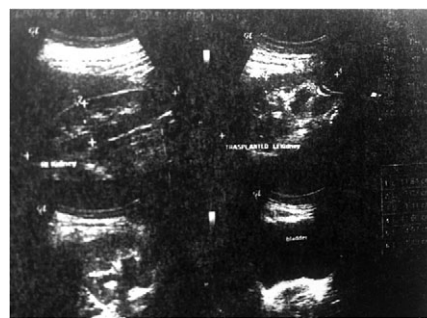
Gray-scale ultrasonography of the patient's transplanted kidney 8 months after surgery.
